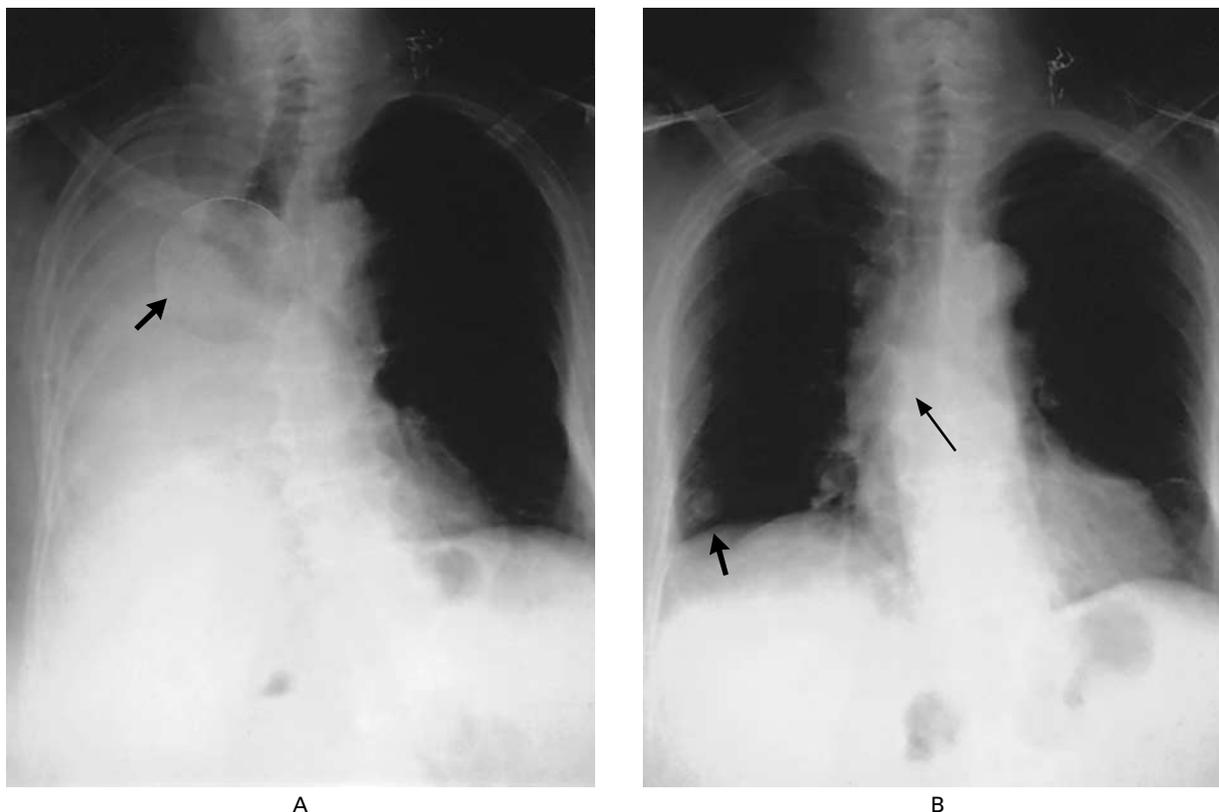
Chest Radiographs of a 66-Year-Old Woman with Severe Dyspnea and Hemoptysis and a History of Endometrial Carcinoma. Complete atelectasis of the right lung was noted, with an ipsilateral shift of the trachea and mediastinum and a bulging mass in the region of the right main bronchus (Panel A, magnified area, arrow). Diagnostic bronchoscopy showed a fungating tumor emanating from the orifice of the right main bronchus and extending into the distal trachea. Nd:YAG-laser photocoagulation was performed, with debulking of the endobronchial tumor and insertion of a metal stent (Wallstent) in the right main bronchus (Panel B, long arrow). A metastatic focus is visible in the inferolateral aspect of the right lower lobe (short arrow).
